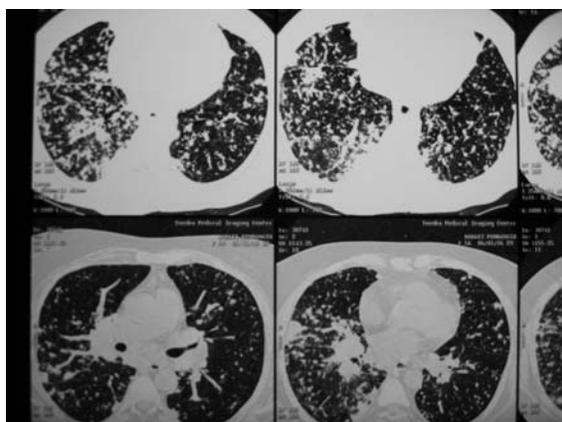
Chest CT-scan of patient with CMV pneumonitis
